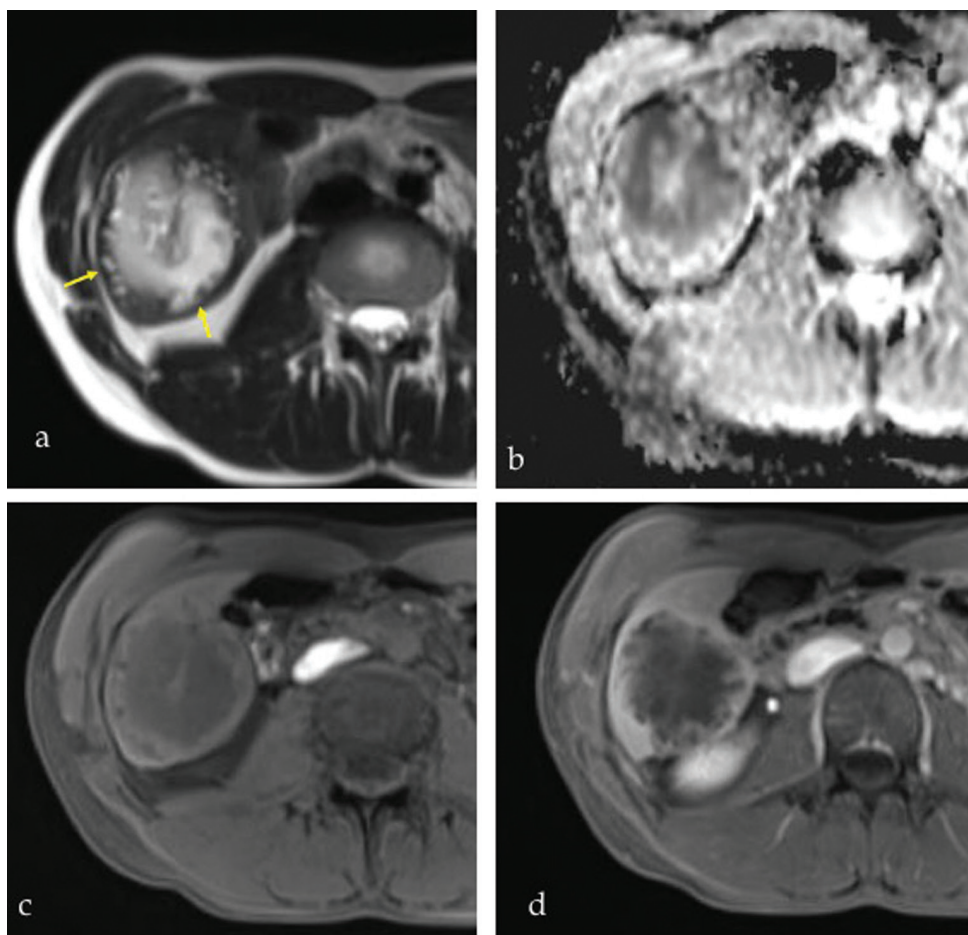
Hydatid cyst. a. T2W magnetic resonance imaging shows complex cyst with peripheral daughter cysts (arrows). b. Apparent diffusion coefficient map shows internal restriction of diffusion. c. Pre- and (d) post-contrast T1W images show rim enhancement.
